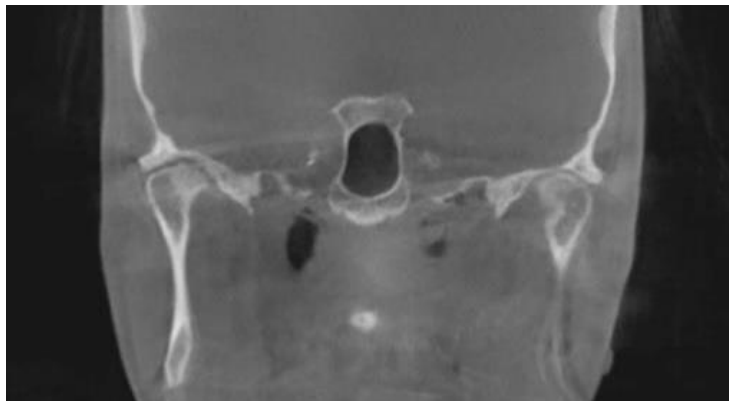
Osteoarthritis of the left condyle at 2 years postoperatively using cone-beam computed tomography.
